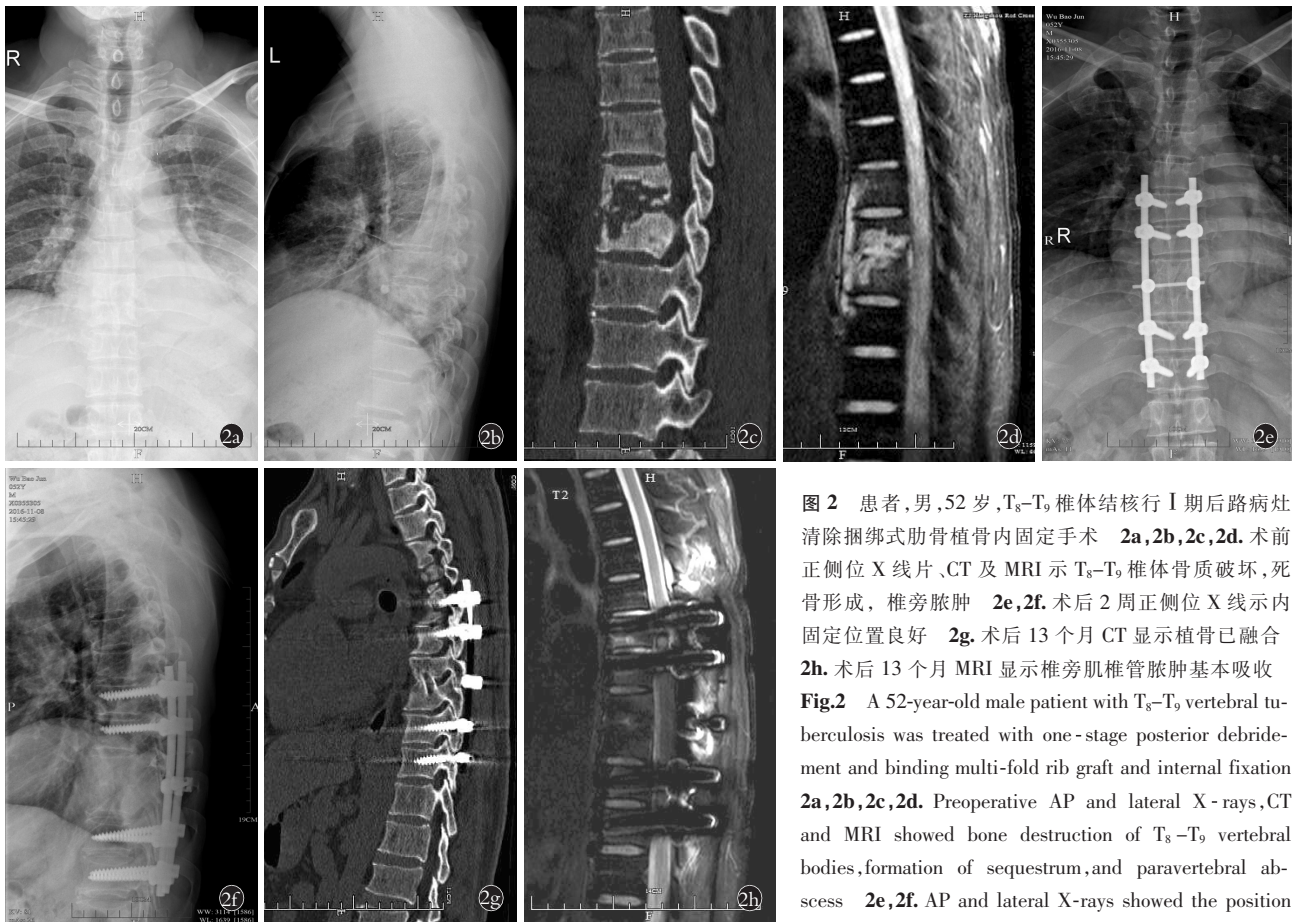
患者,男,52 岁,T₈-T₉ 椎体结核行 I 期后路病灶清除捆绑式肋骨植骨内固定手术 2a,2b,2c,2d. 术前正侧位 X 线片、CT 及 MRI 示 T₈-T₉ 椎体骨质破坏,死骨形成,椎旁脓肿 2e,2f. 术后 2 周正侧位 X 线示内固定位置良好 2g. 术后 13 个月 CT 显示植骨已融合 2h. 术后 13 个月 MRI 显示椎旁肌椎管脓肿基本吸收 Fig.2 A 52-year-old male patient with T₈-T₉ vertebral tuberculosis was treated with one-stage posterior debridement and binding multi-fold rib graft and internal fixation 2a,2b,2c,2d. Preoperative AP and lateral X-rays,CT and MRI showed bone destruction of T₈-T₉ vertebral bodies,formation of sequestrum,and paravertebral abscess 2e,2f. AP and lateral X-rays showed the position of internal fixation was good at 2 weeks after operation
